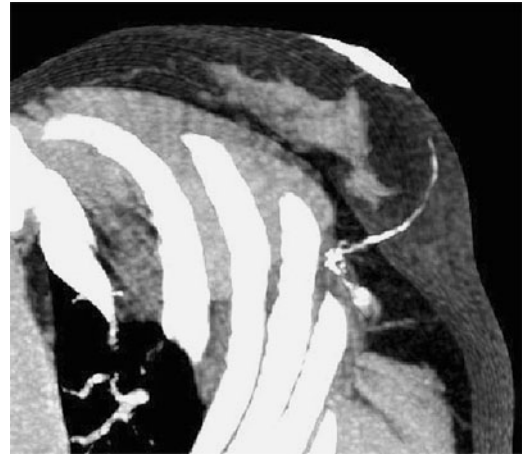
CT lymphography in a negative SLN (3 min image); SLN - small arrow, breast nipp after contrast medium injection - curved arrow
